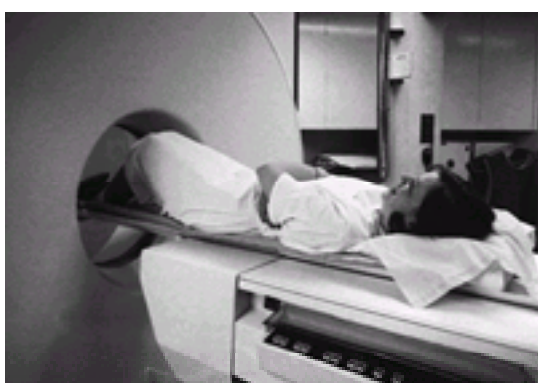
The usual examination position for patients undergoing CT. Greater comfort is provided by using the support behind the knees.
